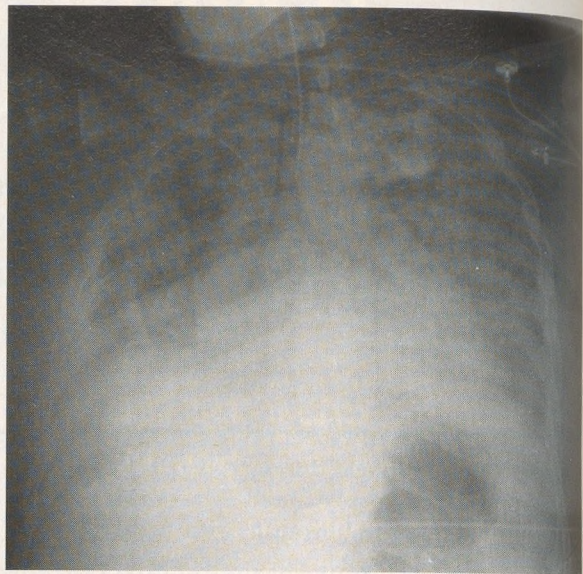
Chest radiograph 8 hours after admission showing diffuse airspace disease and a right pleural effusion.
